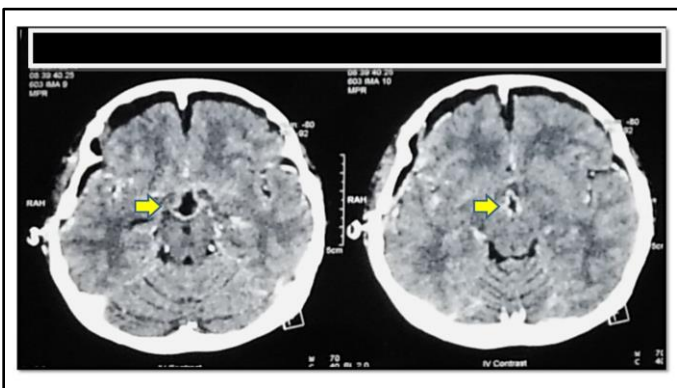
Post-operative cranial CT scan with contrast showing a decreased size of the mass.
